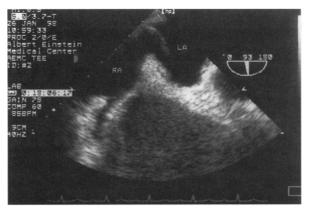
Transesophageal echocardiogram demonstrates patent foramen ovale.
